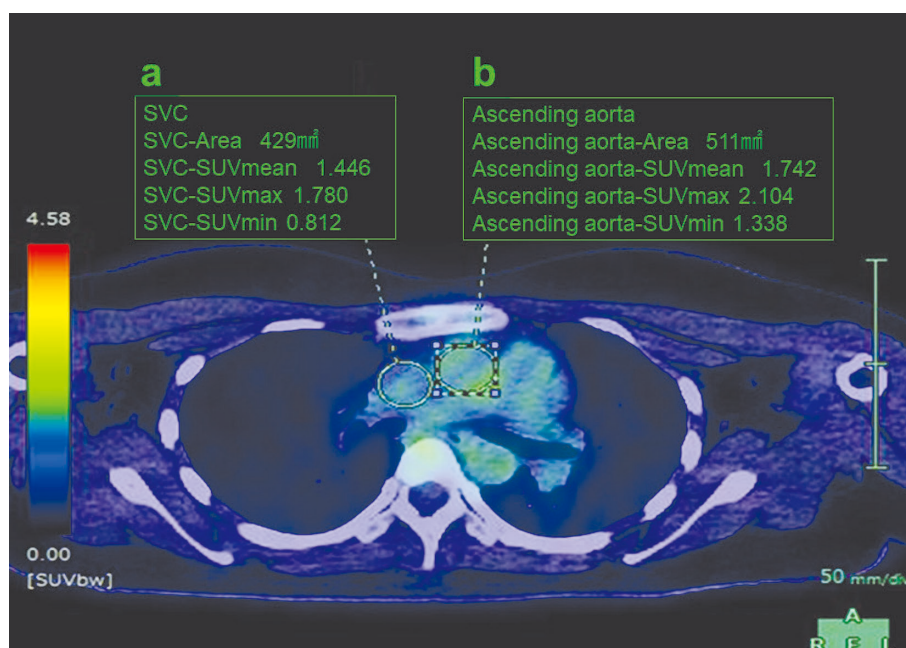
Example of image measuring standardized uptake values (SUV) on PET/CT image.
